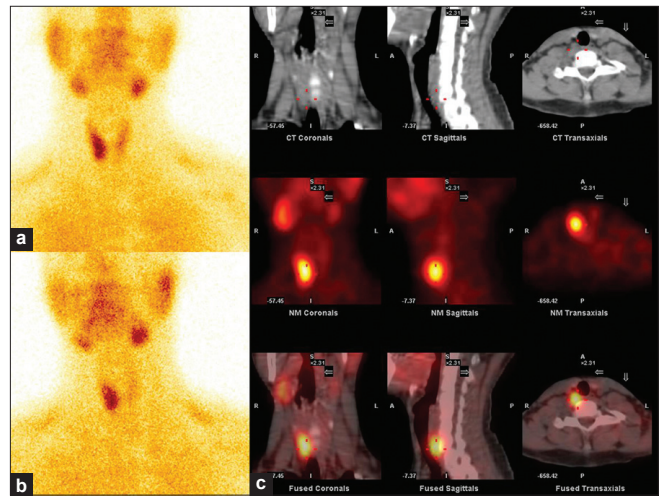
A 17-year-old male had history of pancreatitis and raised parathyroid hormone. (a) Early images of Tc99m sestamibi show increased tracer uptake in the lower part of right lobe of the thyroid. (b) Retention of the tracer is seen in the right lobe in delayed images. (c) SPECT/CT localizes abnormal tracer uptake to a soft tissue mass in the prevertebral region (right of the midline) opposite the 7th cervical vertebra
